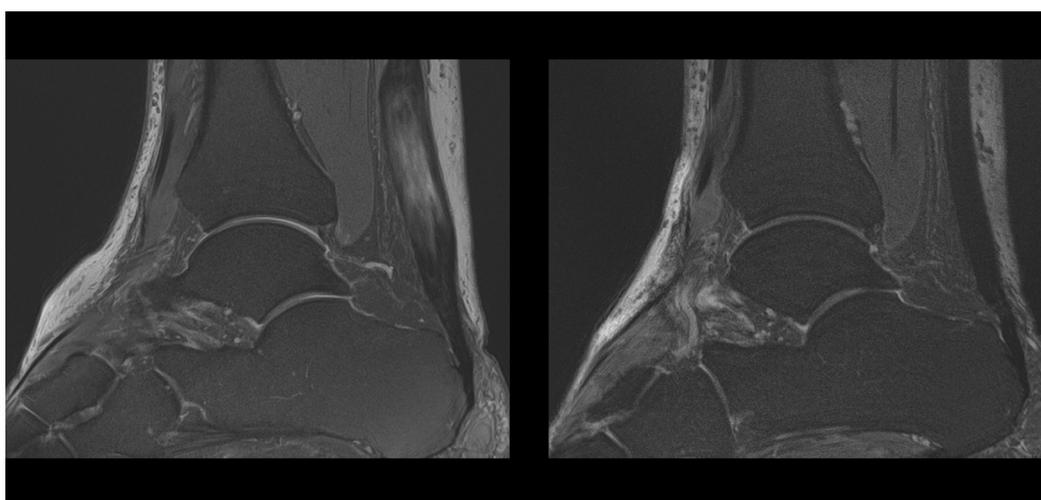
(Case 2): A 70-year-old patient with a four-year history of chronic partial rupture of the Achilles tendon insertion in the left ankle, who failed prior conservative treatment. A) T2-weighted magnetic resonance imaging (MRI) before local autologous bone marrow mesenchymal stem cell (aBM-MSC; 20×10^6 cells) injection. Presence of tissue 46.0%. B) T2-weighted MRI at 12 months post-aBM-MSC injection. Almost complete tissue regeneration of chronic partial Achilles tendon rupture (96%) was achieved. No adverse events. The patient resumed hiking after four months.
